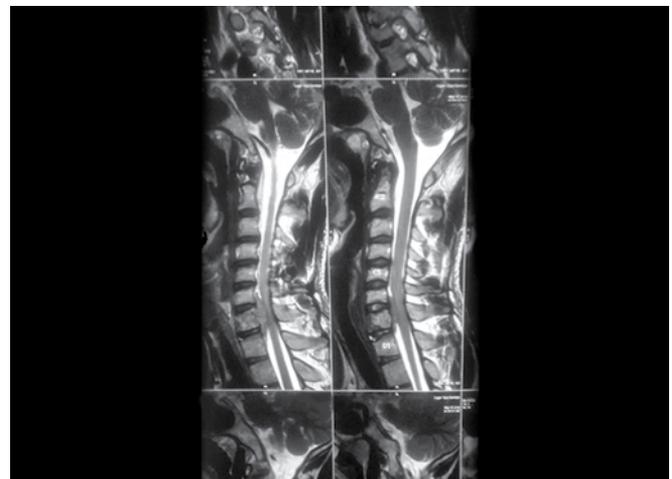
Preoperative T2-weighted sagittal section of MRI cervical spine reveals lytic lesion in body of C7 vertebra with extradural soft tissue compressing the spinal cord. No evidence of cord signal intensity changes
